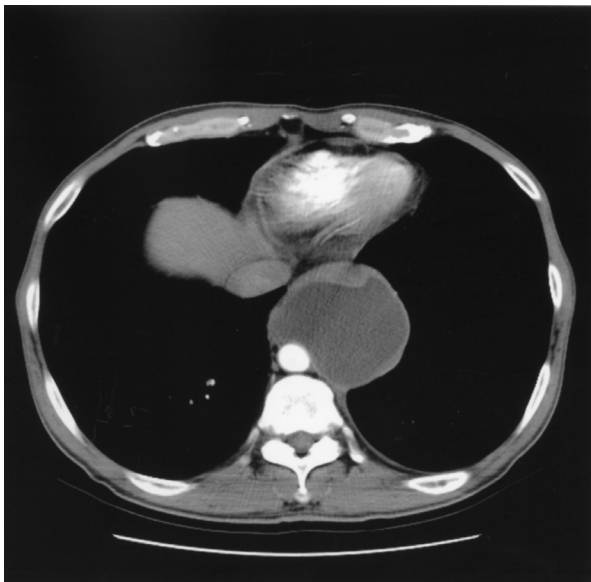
CT scan showing a thick-walled, cystic, low-attenuation mass in the posterior mediastinum.
